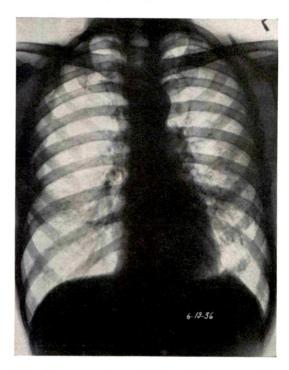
Roentgenogram of chest of Case xvi, after six months of radiation therapy. Note diffuse thickening in left lung field and adhesions at base.
